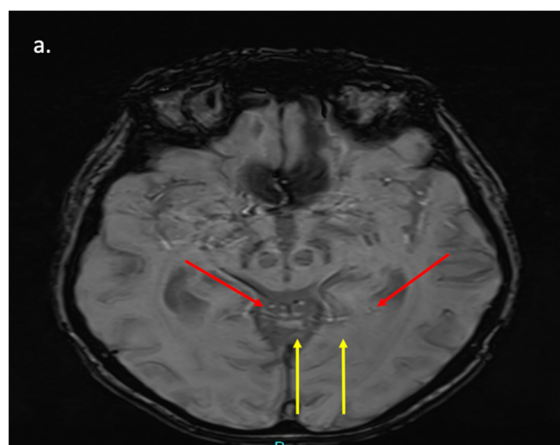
MRI Brain Image Highlighting Key Regions Commonly Affected in Parkinson's Disease (PD). Axial T2*-weighted MRI at the level of the midbrain in a healthy control brain. The image demonstrates normal susceptibility-related signal dropout in the substantia nigra pars compacta (red arrows) and red nucleus (yellow arrows), reflecting typical iron deposition patterns seen in non-pathological aging.
